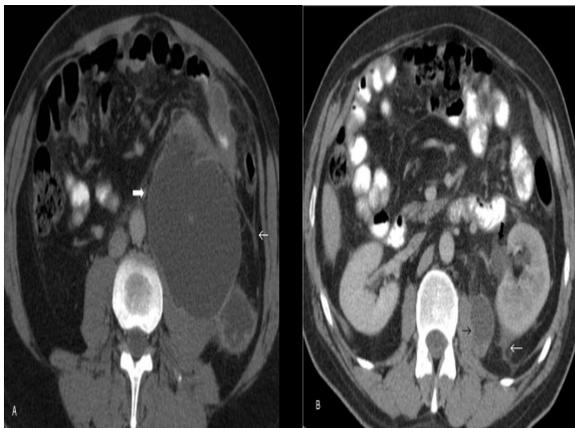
Axial computed tomography scan of the abdomen. (A) A retroperitoneal multiloculated cystic mass is indenting the left psoas muscle (thick arrow), and lateroconal fascial thickening is present (thin arrow). (B) Grade 1 hydronephrosis (thick black arrow), posterior perirenal fluid (white arrow), and a cystic mass anterior to the left psoas muscle (thin black arrow) are evident.
